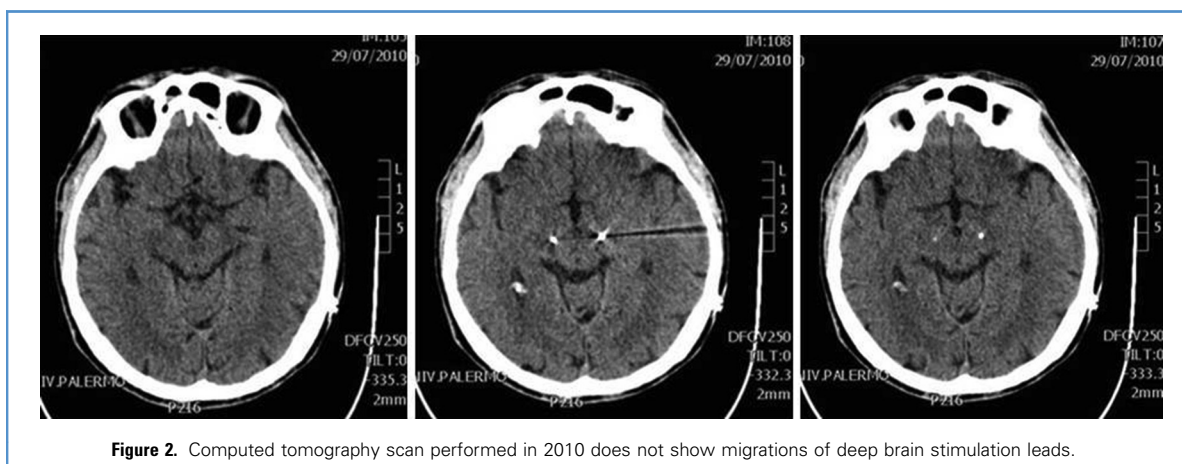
Computed tomography scan performed in 2010 does not show migrations of deep brain stimulation leads.
